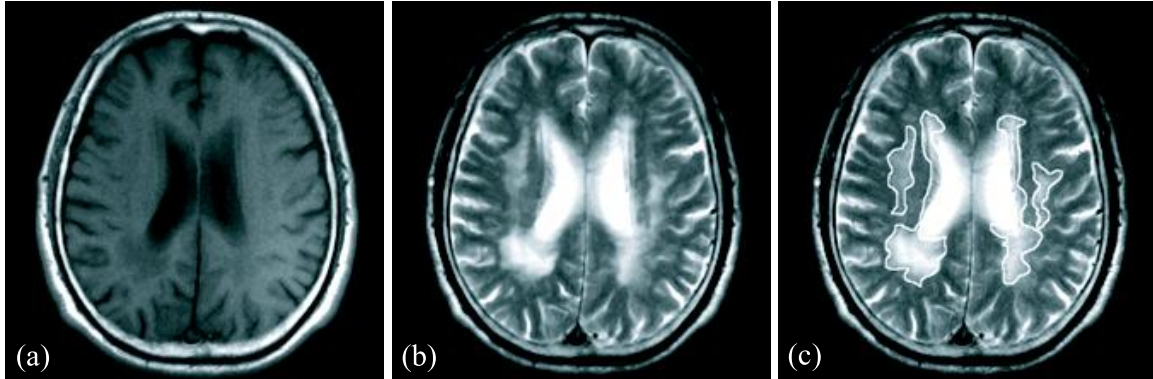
Examples of leukoaraiosis. (a) T1-weighted image. (b) T2-weighted image. (c) Leukoaraiosis regions determined by an experienced neuroradiologist superimposed on the T2-weighted image. The white lines indicate an abnormal area of leukoaraiosis. Leukoaraiosis exhibits high and relatively low signal intensities in T2- and T1-weighted images, respectively.
